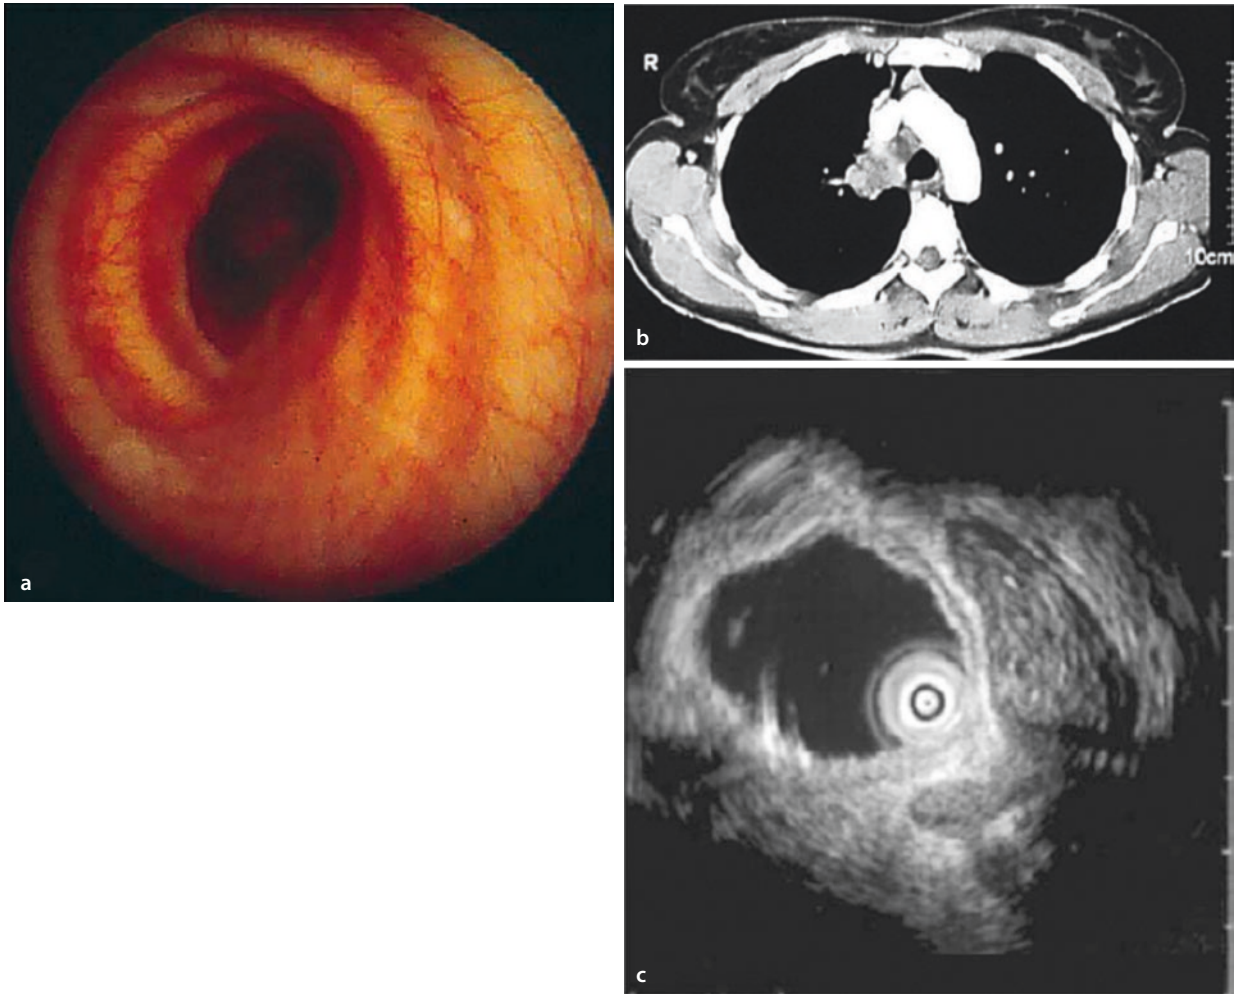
Compression of the trachea by a tumor. (a) Bronchoscopy reveals an impression of the trachea. (b) The corresponding CT image shows a mass in the upper lobe. (c) Ultrasound reveals a well-defined tumor; an infiltration is unlikely
